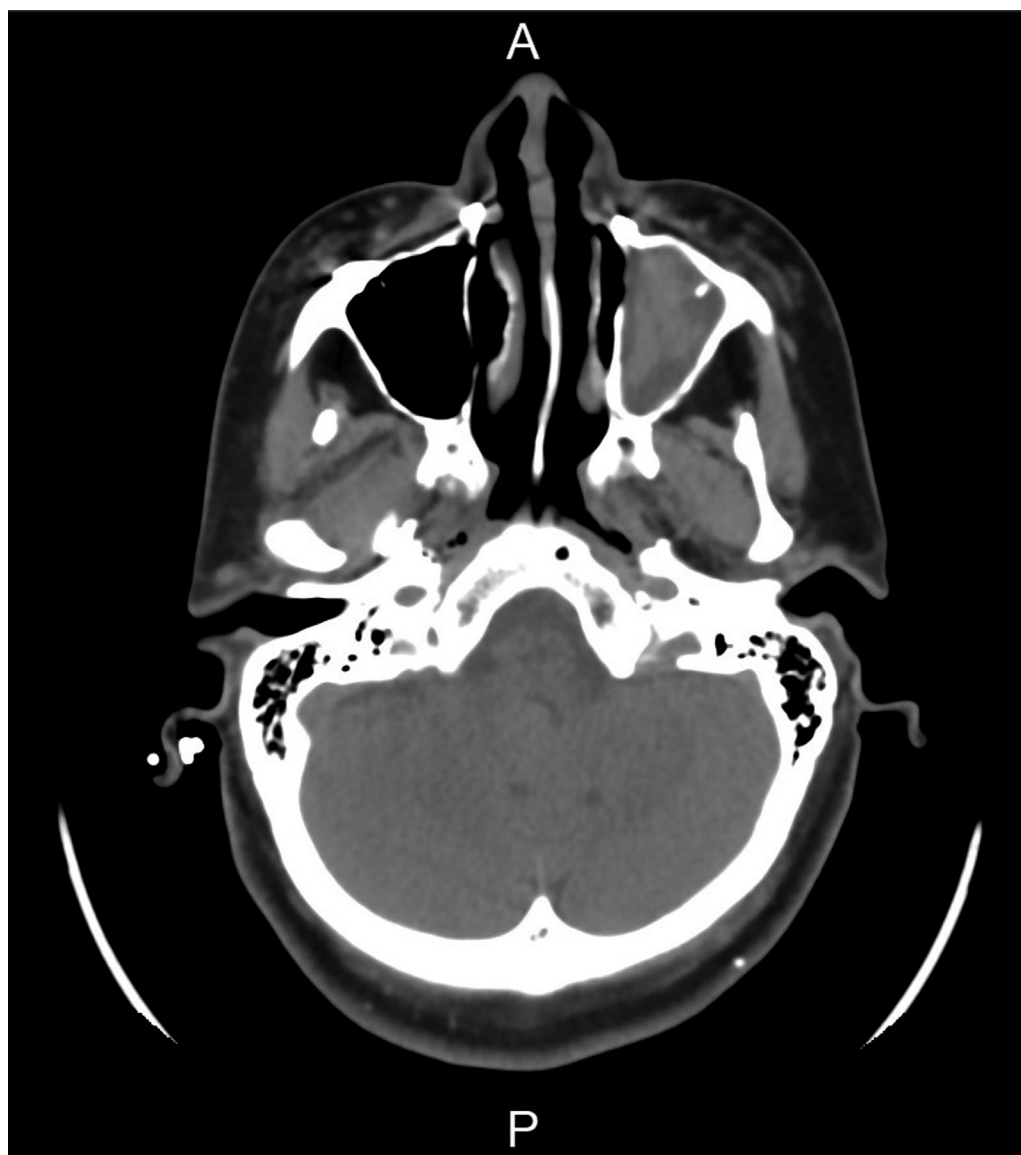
Axial CT image of the skull showing complete opacification with hyperdense fluid content of the left maxillary sinus.
